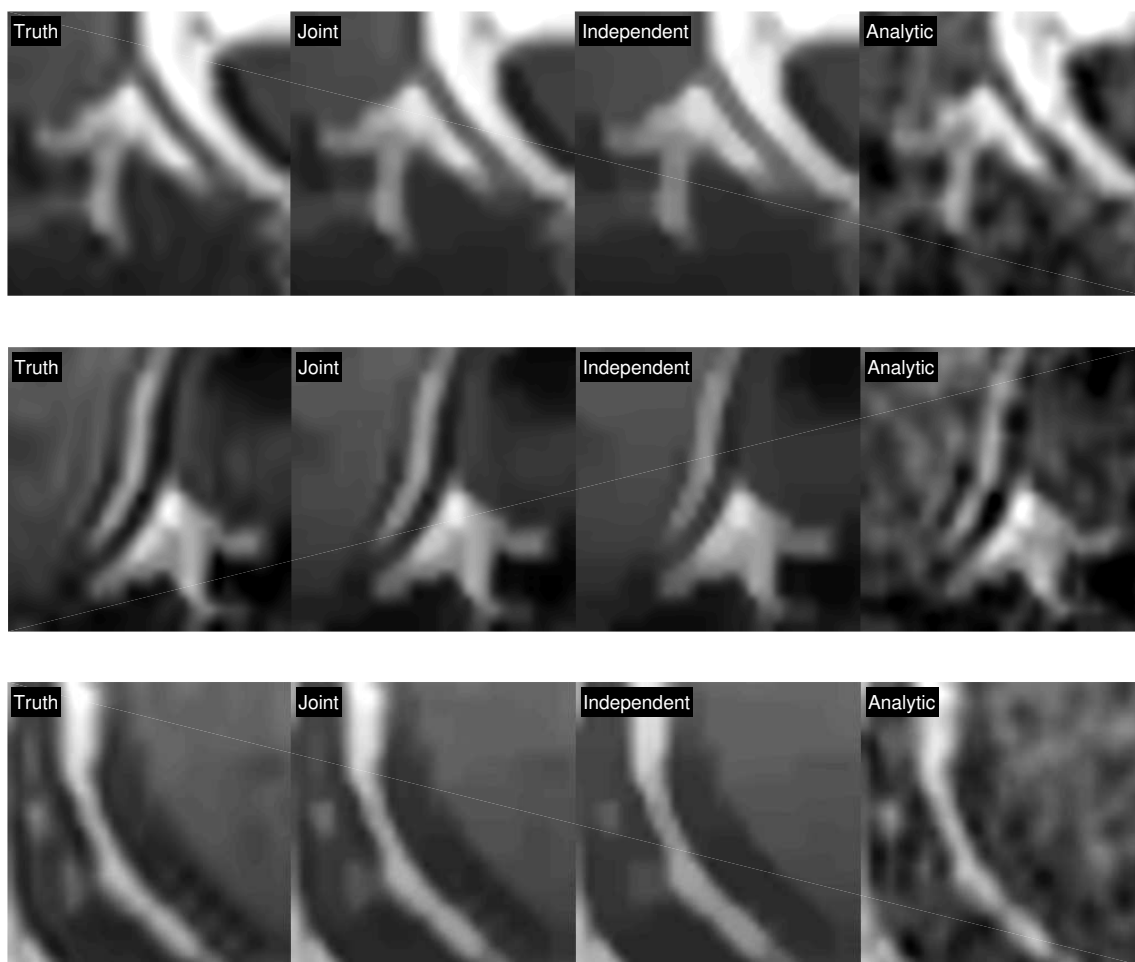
ROI comparison for MRI images with all three ROIs being defined in Fig. 5.4 shown in red; All ROIs are zoomed in with zoom factor of $8\times$. Display window is $[0\ 1]$.
